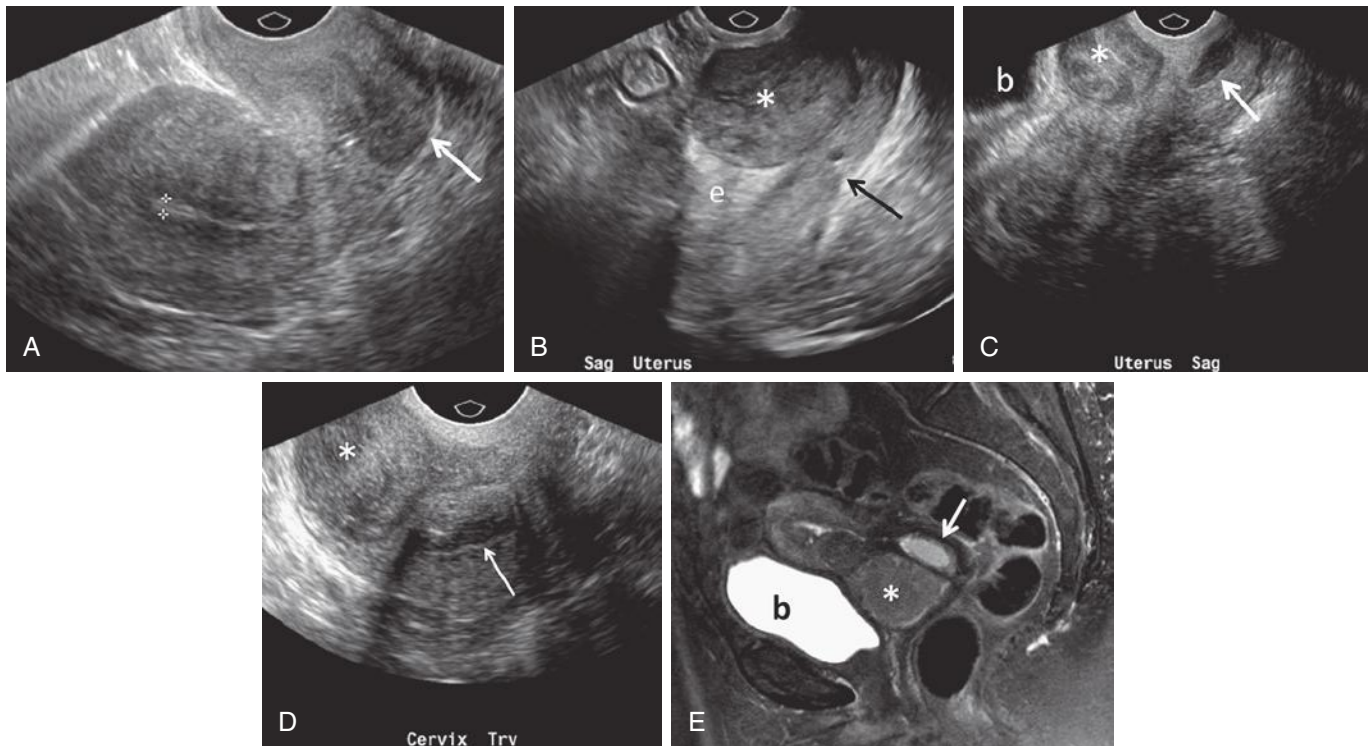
Cervical leiomyomas. A, Note hypoechoic mass (*arrow*) arising within the posterior wall of the cervix but separate from the endocervical canal, which appears normal, suggesting that this is not a cervical carcinoma but a lesion arising from the muscular layer of the cervix. Note normal endometrium (*calipers*). B, Large exophytic mass (*asterisk*) arising from the anterior wall of the cervix but extending into the lower uterine segment in a second patient with a cervical leiomyoma. There is a small anechoic nabothian cyst in the posterior wall of the cervix, just below the level of the internal os (*arrow* at indentation between the lower uterine segment and upper cervix). e, endometrium. C and D, Sagittal and transverse transvaginal gray-scale images from a third patient with an exophytic cervical leiomyoma (*asterisks*) that is clearly separate from the endocervical canal, which is distended with anechoic fluid (*arrows*). This cervical leiomyoma also extends into the lower uterine segment. b, bladder. E, Sagittal T2-weighted fat saturation magnetic resonance image of the same patient as in C and D demonstrates similar findings. Low signal intensity cervical leiomyoma (*asterisk*) extends into the lower uterine segment; endocervical canal is distended with high signal intensity fluid (*arrow*). b, bladder.
